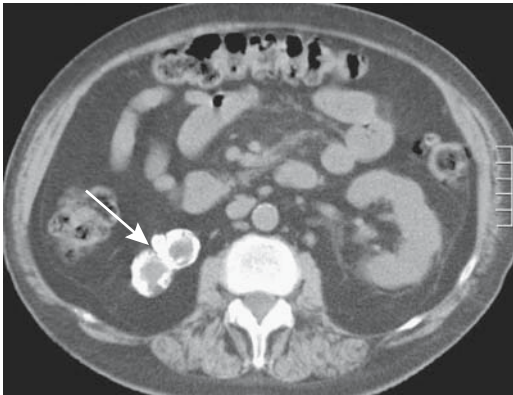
Right multicystic dysplastic kidney. Noncontrast computed tomography (CT) identifies a small, irregular right kidney (arrow). (Courtesy of Nancy Curry, M.D., Medical University of South Carolina.)
